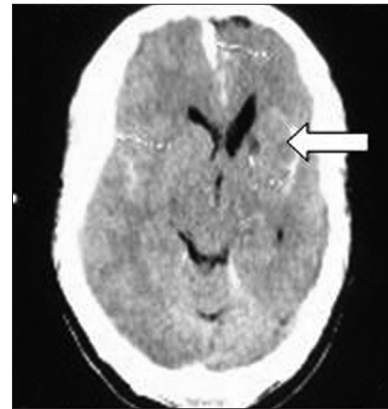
Axial computed tomography showing small infarct in left caudate region suggestive of old infarct
